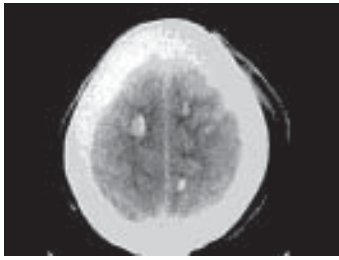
CT Brain in a case of head injury with Diffuse Axonal Injury showing multiple lesions ovoid to elliptical in shape, ranging in size from 5 to 15 mm. They are usually nonhemorrhagic in nature.
